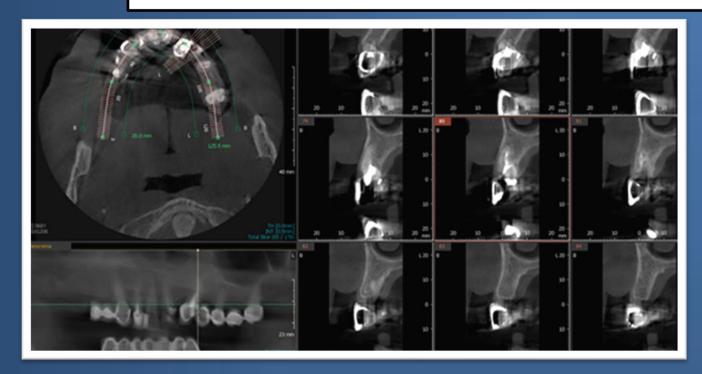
3D CT of the upper jaw
